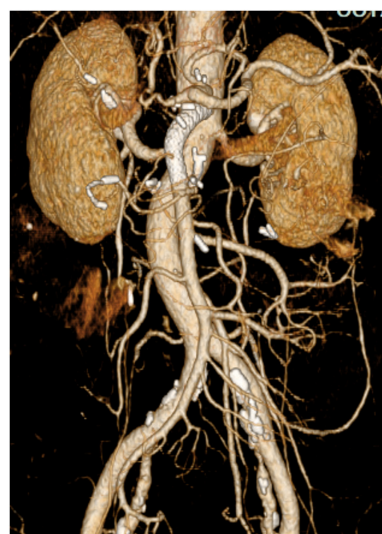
E-CT with 3-dimensional reconstruction shows complete closure of the SMAVF. E-CT: enhanced computed tomography; SMAVF: superior mesenteric arteriovenous fistula
